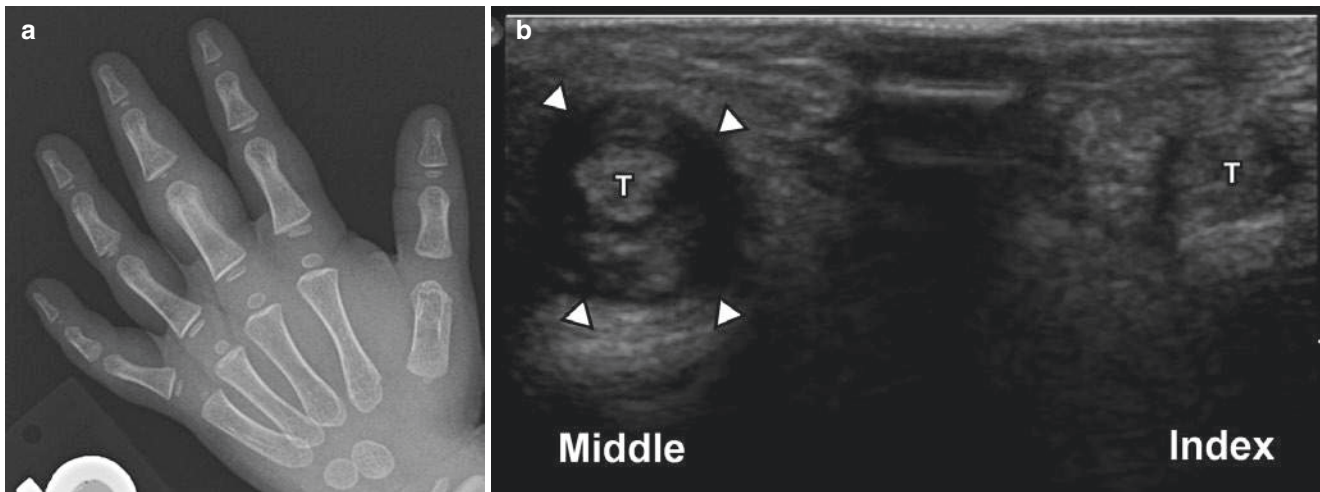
Seventeen month-old girl with polyarticular rheumatoid factor-negative juvenile idiopathic arthritis. (a) Posteroanterior radiograph of the left hand shows soft tissue swelling of the middle finger. Mild swelling of other fingers is not well appreciated. Paradoxically, the epiphysis
